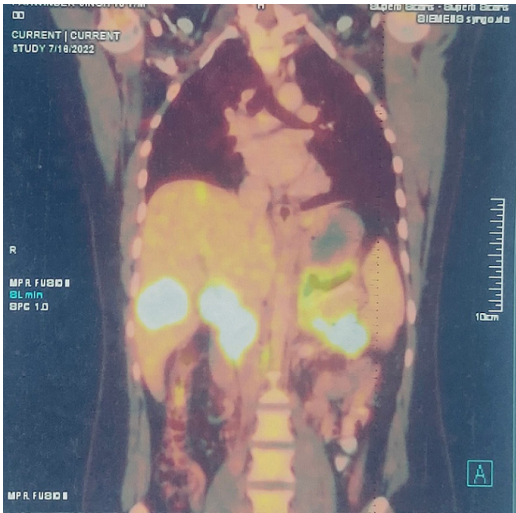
Pet CT Showing Hypermetabolic Activity with Increased SUV Uptake in Gall Bladder and Liver and Lymph Nodes.
